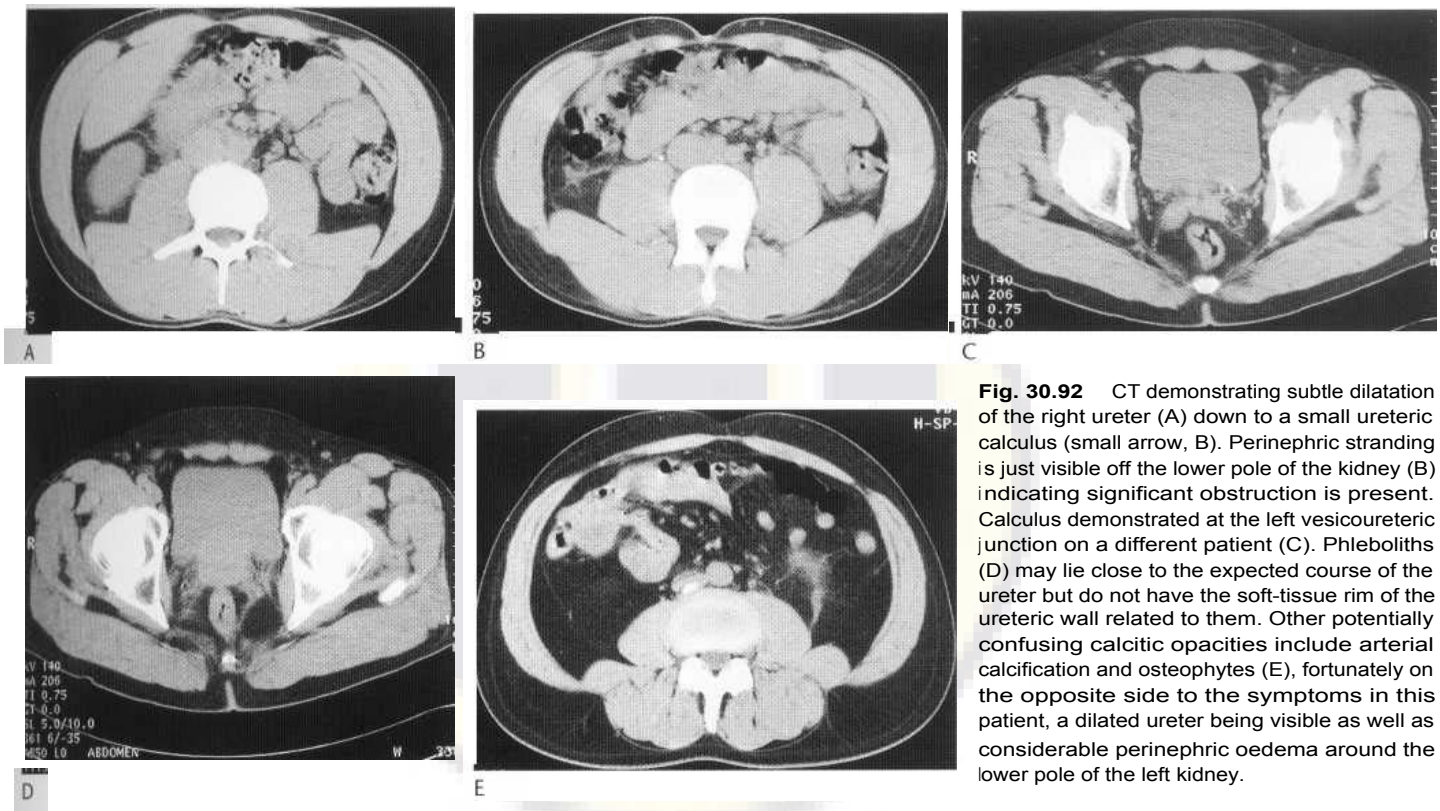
CT demonstrating subtle dilatation of the right ureter (A) down to a small ureteric calculus (small arrow, B). Perinephric stranding is just visible off the lower pole of the kidney (B) indicating significant obstruction is present. Calculus demonstrated at the left vesicoureteric junction on a different patient (C). Phleboliths (D) may lie close to the expected course of the ureter but do not have the soft-tissue rim of the ureteric wall related to them. Other potentially confusing calcific opacities include arterial calcification and osteophytes (E), fortunately on the opposite side to the symptoms in this patient, a dilated ureter being visible as well as considerable perinephric oedema around the lower pole of the left kidney.
